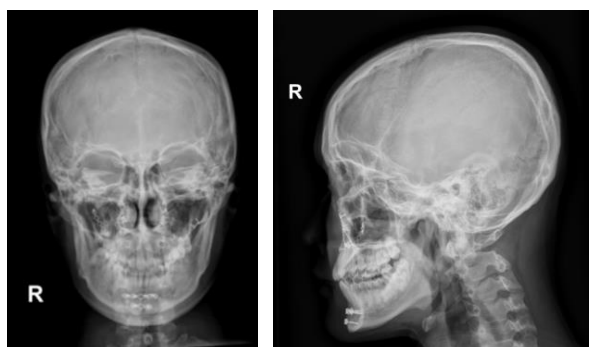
Photo X-ray Skull anteroposterior dan lateral.
